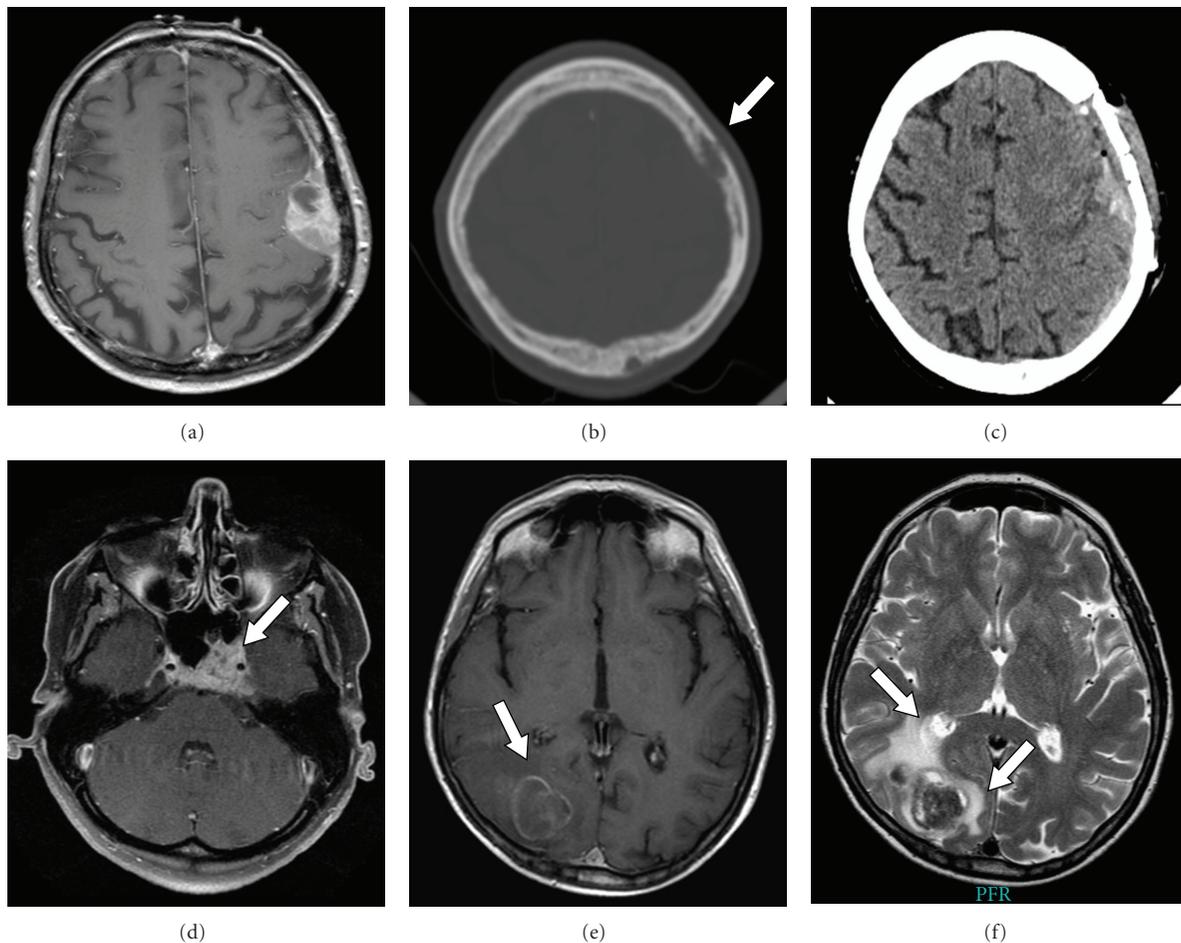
(a)–(c) 77-year-old female with aphasia resulting from breast cancer dural metastasis, (a) preoperative T1-weighted MRI showing contrast enhancement of a left parietal dural tumor. (b) Preoperative CT scan shows bone erosion (arrow). (c) Postoperative CT scan documents the removal of the dural mass and the infiltrated bone which has been substituted by bone cement cranioplasty. (d) T1-weighted MRI showing contrast-enhancing breast cancer skull base metastasis in the clival region occurring in a 45-year-old female with known breast cancer and diplopia (arrow). (e, f) MRI of a 69-year-old female with right occipital breast cancer brain metastases. (e) T1-weighted MRI shows a ring-like contrast-enhancing lesion (arrow). (f) T2-weighted MRI shows the lesion with significant peritumoral finger-like edema (arrows).
